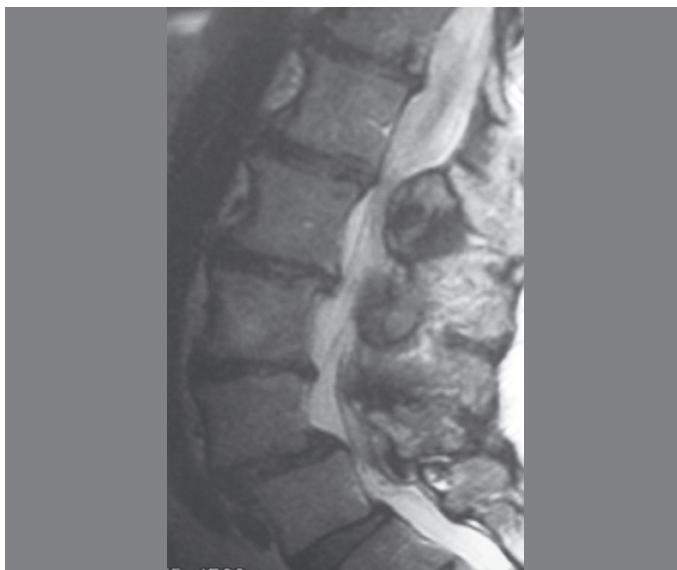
MRI T2-weighted: Aspect of the L1–L2 lesion with a peripheral hypointense image and hyperintense in its interior.
